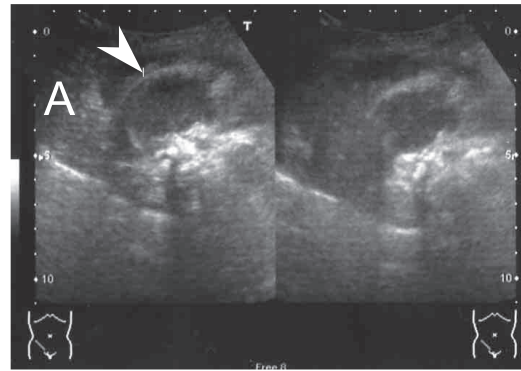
(A)US finding, (B)CT finding, (C)MRI T2-weighted finding.
